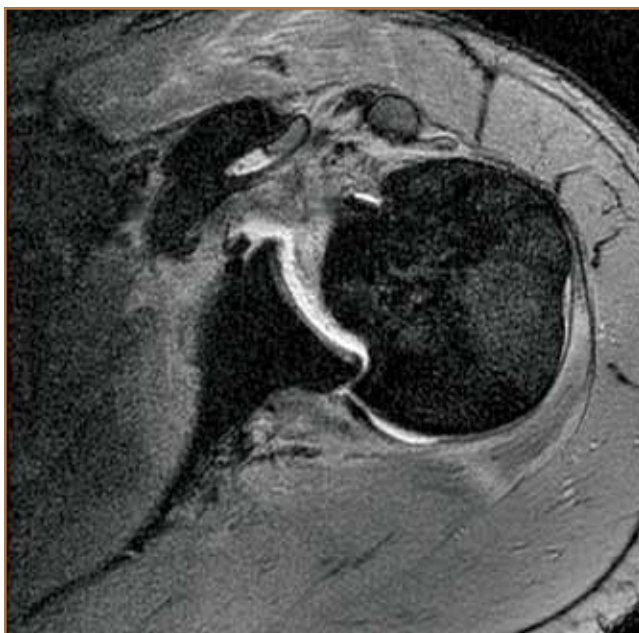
Axial T2-weighted MRI arthrogram of the left shoulder, taken 2 weeks postinjury, demonstrating a posterior glenohumeral dislocation, with large reverse Hill-Sachs lesion, and complete tear of the subscapularis.
